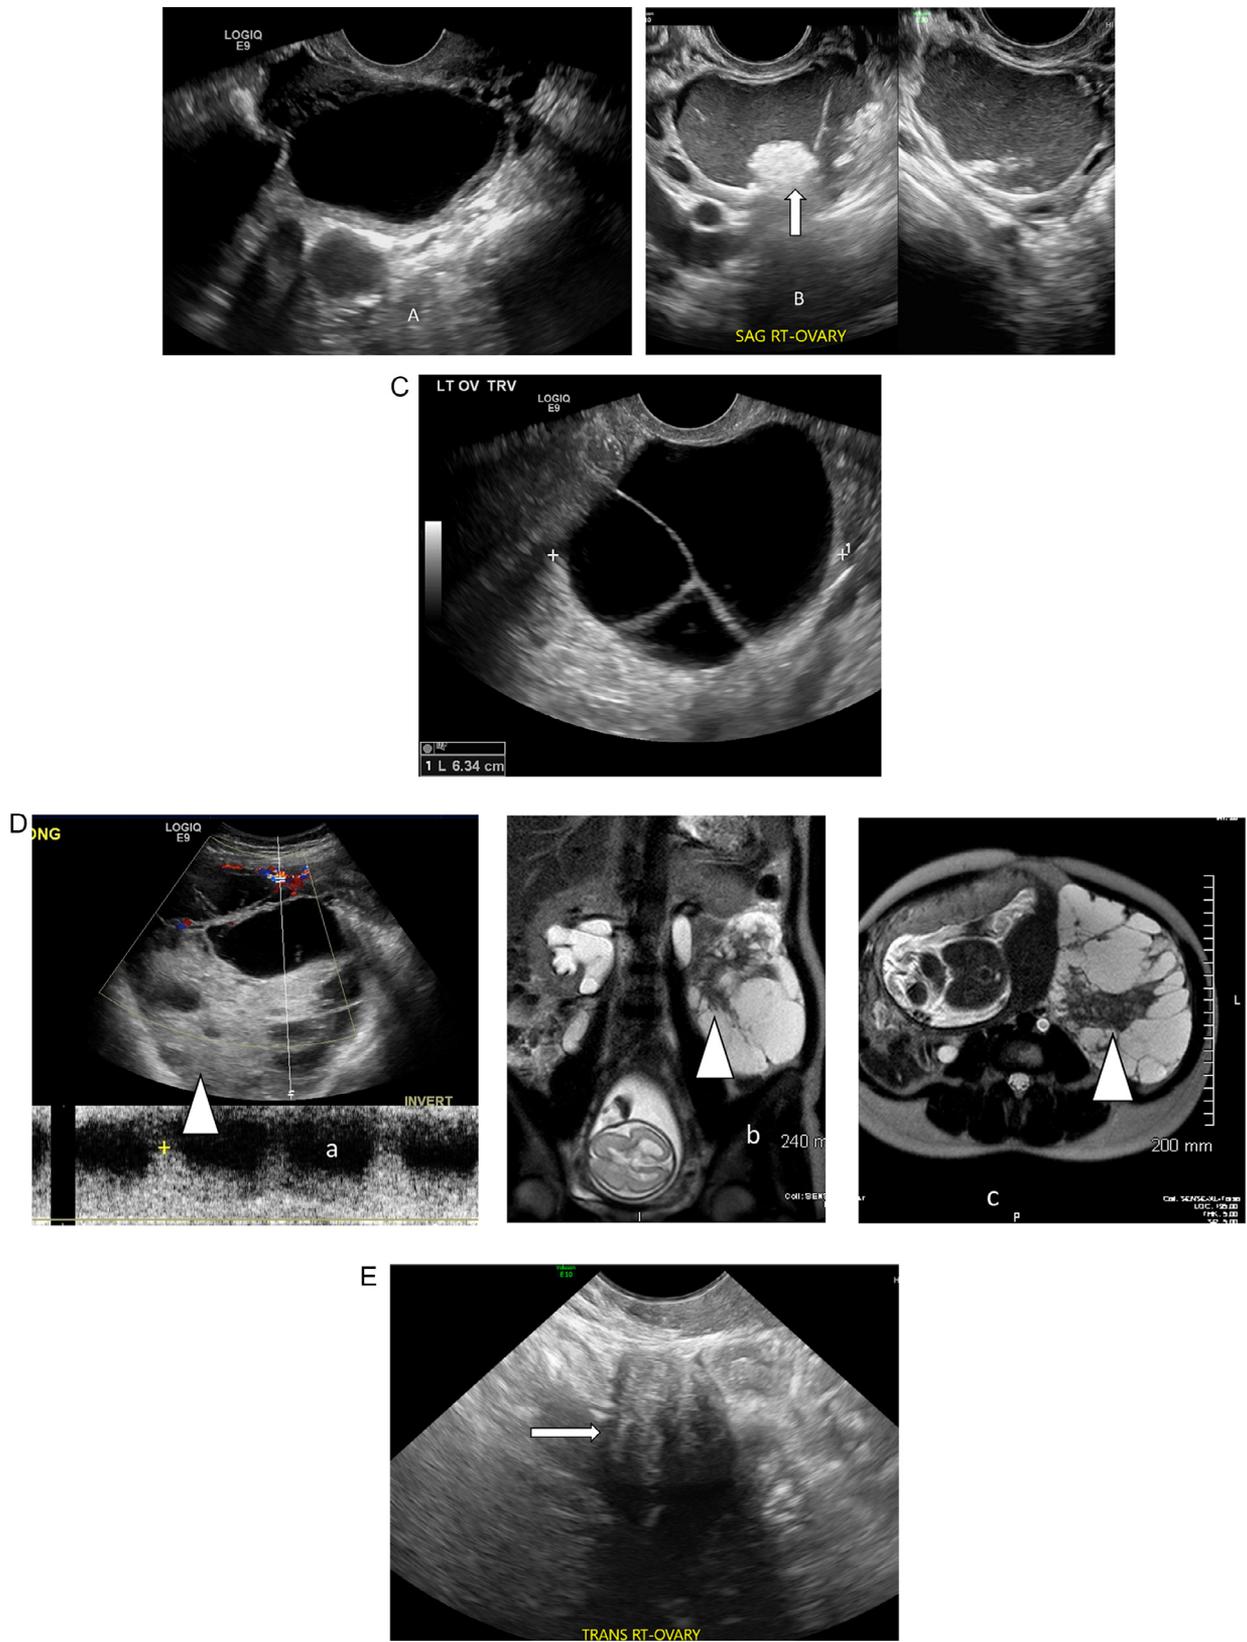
(A) Unilocular cyst. (B) Unilocular solid mass. A unilocular cyst with mixed echogenic internal contents and a solid component (arrow) with shadowing characteristic of a dermoid. (C) Multilocular cyst without solid components. A cystic adnexal tumor with multiple complete septations. (D) Ultrasound (a) and T2-weighted coronal (b) and axial MRI(c) images of a multiloculated cystic mass with solid components (arrowheads) surgically proven to be a yolk sac tumor in a pregnant woman. (E) Solid tumor of the ovary (arrow) with multiple areas of acoustic shadowing proven to be a fibroma.
